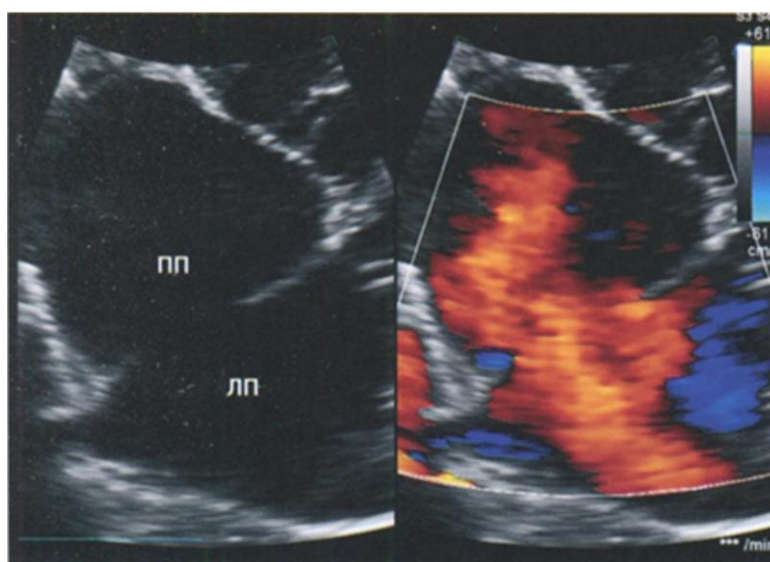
Heart ultrasound.
